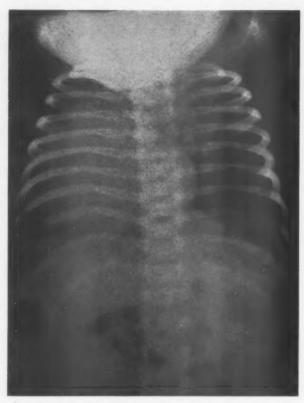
Case 1. Posteroanterior radiograph demonstrating dextrocardia of the "isolated" variety.
